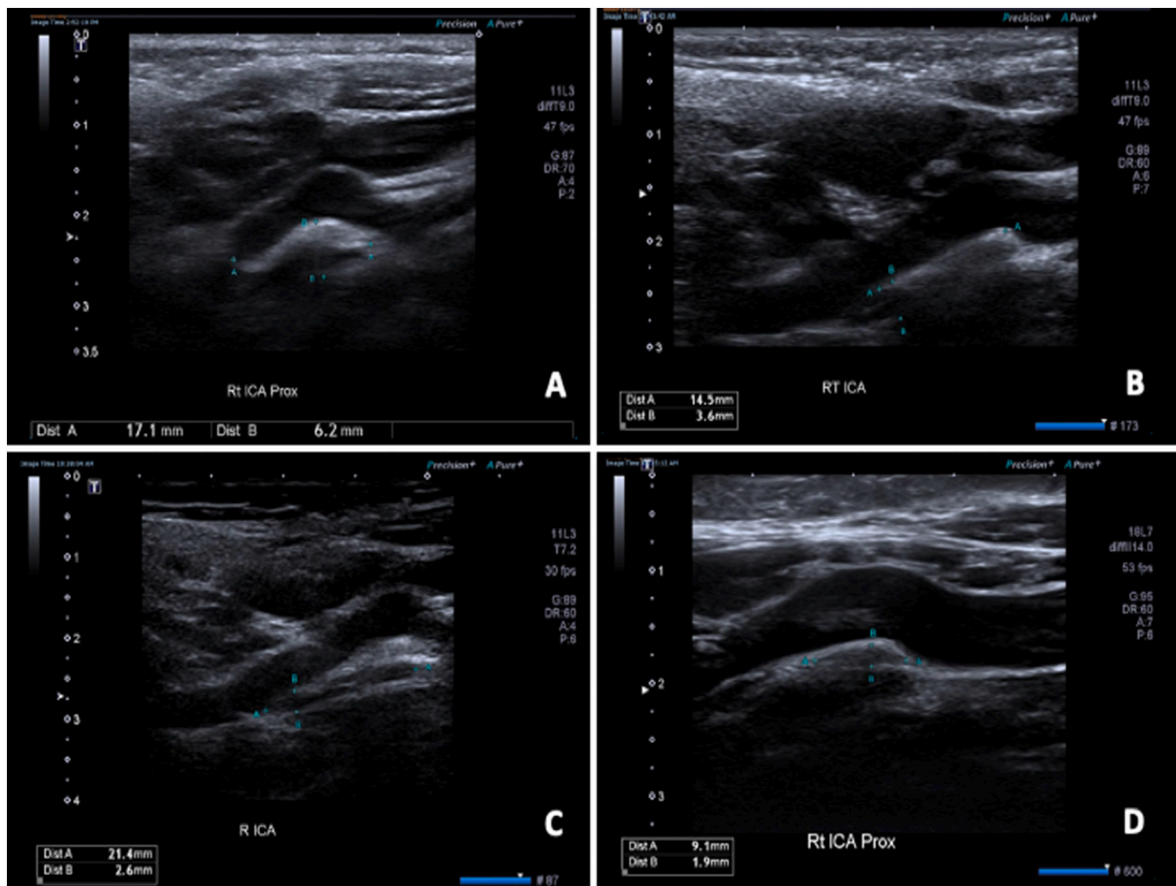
Serial B-mode ultrasound performed at 6 (A), 12 (B), 24 (C) and 48 (D) months demonstrating progressive arterial remodelling.
